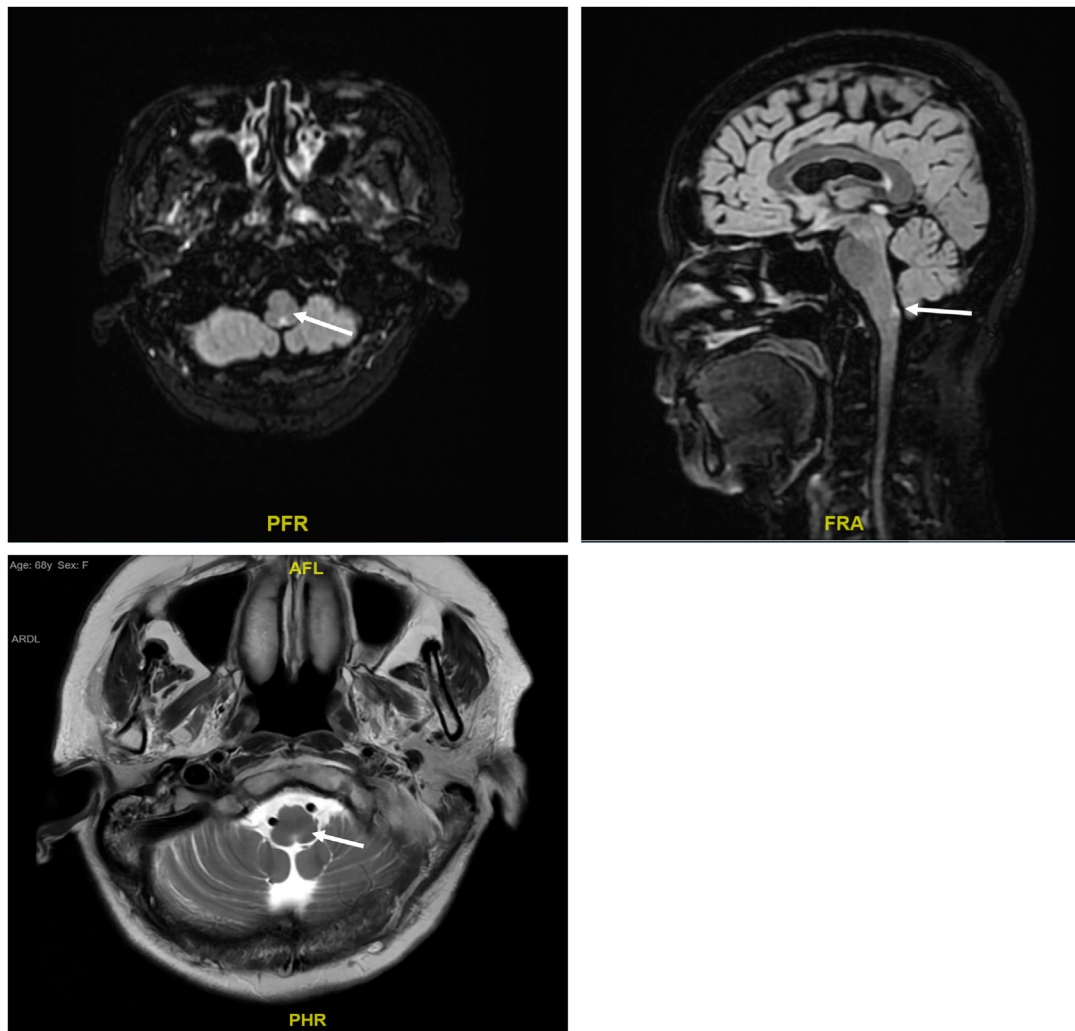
MRI brain showing T2W/FLAIR hyperintense lesions (arrow). From top left: axial view showing FLAIR hyperintense lesion in the posterior aspect of the medulla oblongata; top right: sagittal view showing FLAIR hyperintense lesion in posteroinferior aspect of the medulla oblongata; bottom left: axial view showing T2W hyperintense lesion in the posterior medulla oblongata.
